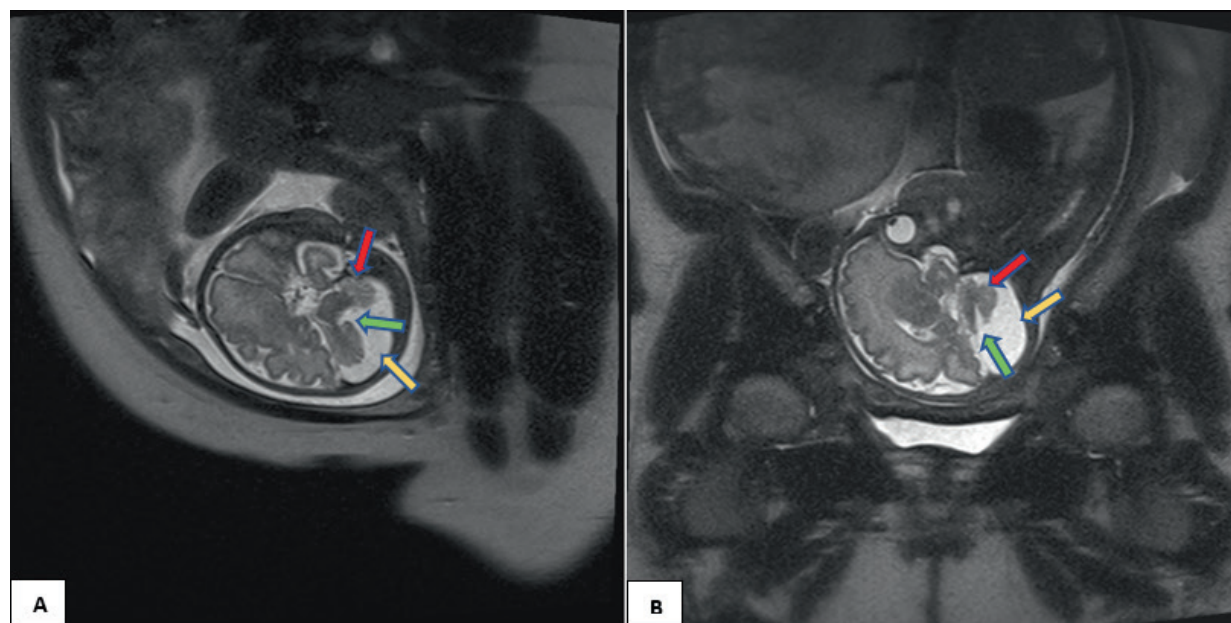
Fetal MRI of T2-weighted half-Fourier acquisition single-shot turbo spin-echo (HASTE) sequence (A) axial, and (B) sagittal presenting absent vermis (green arrows), hypoplastic cerebellum (pink arrows), and posterior fossa dilation (yellow arrows).
